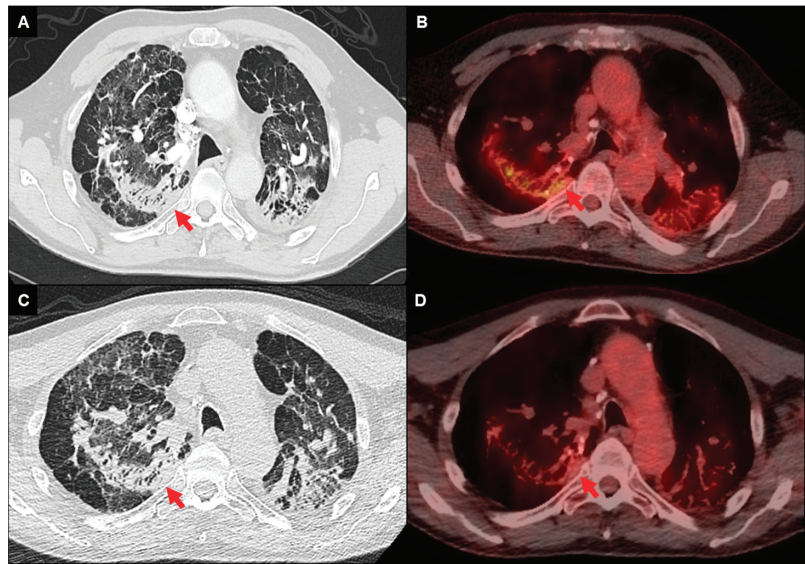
FDG-PET/CT imaging of a 68-year-old male with fibrotic pulmonary sarcoidosis on chronic methotrexate with metabolically active infiltrates (arrows) in the right upper lobe and left upper lobe extending into the pleura (A,B); reduced density and activity on follow-up imaging 12 months after the addition of anti-TNF-alpha inhibitor (C,D).
